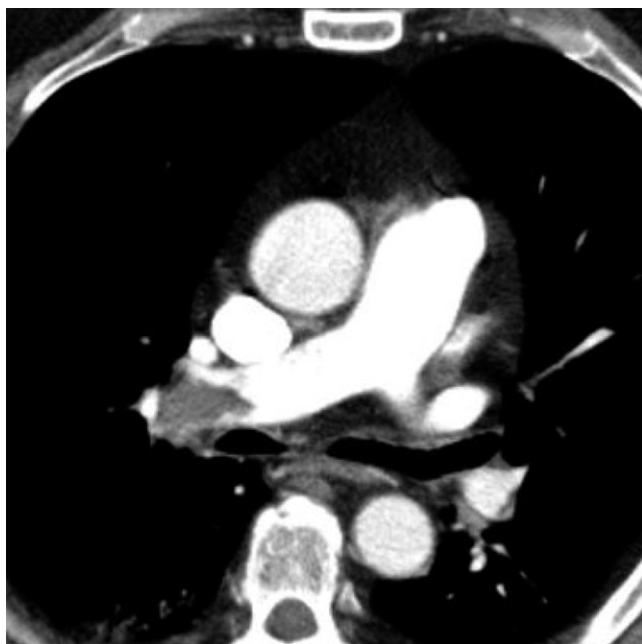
CT pulmonary angiogram showing PE in the right pulmonary artery.
